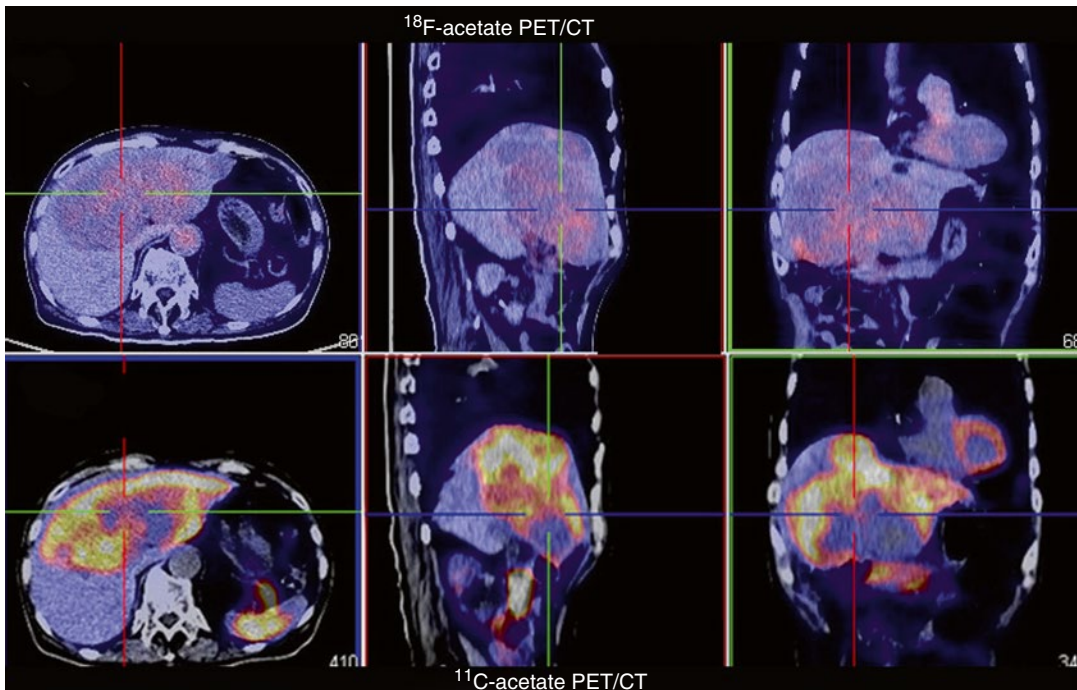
A huge HCC lesion with marked avidity for ¹¹C-acetate but is negative on ¹⁸F-acetate PET/CT
